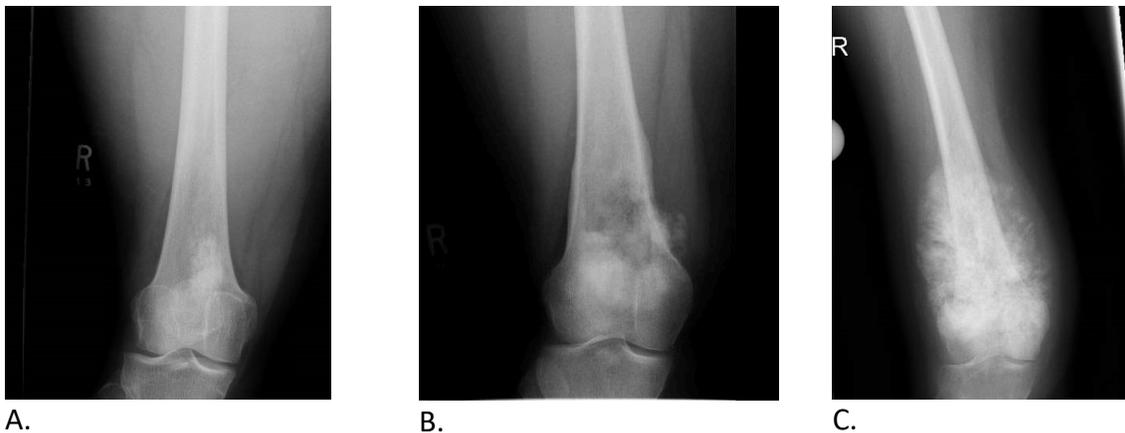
Examples of tumor ossification on plain radiographs AP view of distal femur of three different patients. (A) Minimal ossification of the tumor was demonstrated in this plain radiograph. (B) Moderate ossification of the tumor was demonstrated in this plain radiograph. (C) Extensive ossification was demonstrated in this plain radiograph.
